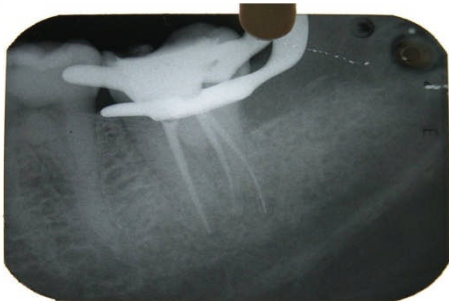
Radiographs after obturation
